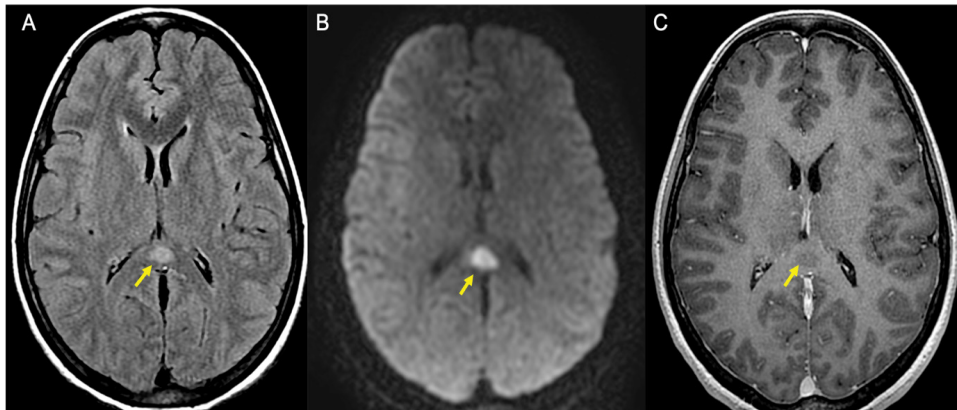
Brain MRI is specific, (A) showing an oval shaped well-defined lesion of the splenium of the corpus callosum (Yellow arrow), with restriction in diffusion (B) and non-enhanced with contrast (C), which is characteristic.
